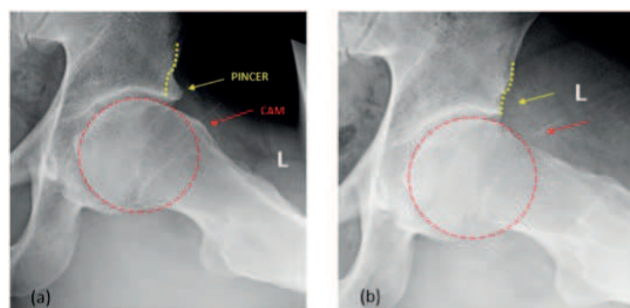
(a) Pre-operative x-ray of a 30-year-old professional athlete with significant pincer and cam deformities consistent with FAI; (b) post-operative x-ray following resection of bony abnormalities
